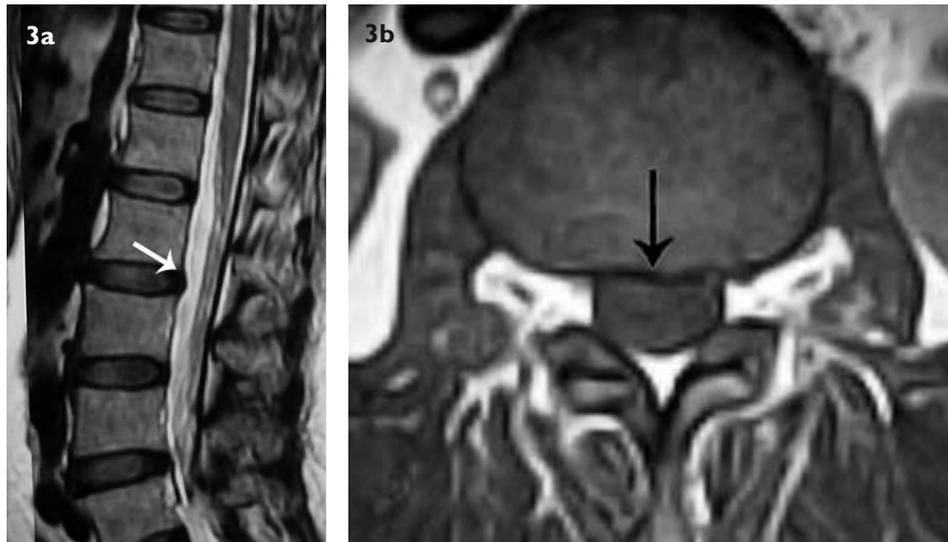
(a) Sagittal T2-W MR image shows disc bulging at L2-L3 level (arrow). (b) Axial T1-W image taken at L2-L3 level shows minimal posterior impression on epidural fat, compatible with disc bulging (arrow).
